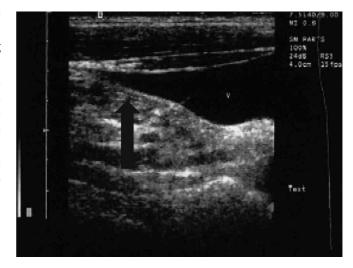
Longitudinal view of the internal jugular vein showing the tapering (black arrow) of the vein in jugular vein distension assessment. Adapted from Figure 1 of Siva B, Hunt A, Boudville N. The sensitivity and specificity of ultrasound estimation of central venous pressure using the internal jugular vein. *J Crit Care*. 2012;27(3):315.e7–315e11. doi:10.1016/j.jcrc.2011.09.008.
